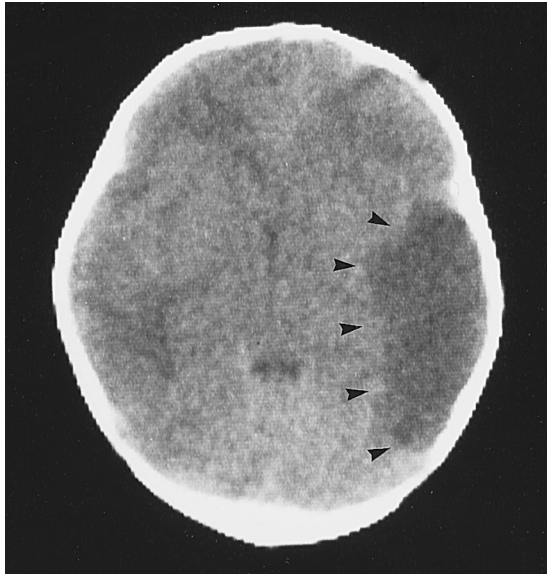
Computed tomography scan of a 3-month-old boy with trisomy 21 and tetralogy of Fallot who, after cardiac catheterization, had focal seizures involving the right side of the face and right arm. Region of hypodensity in the left hemisphere (*arrowheads*) reflects infarction of the left middle cerebral artery territory, most likely caused by embolic occlusion of that vessel.
